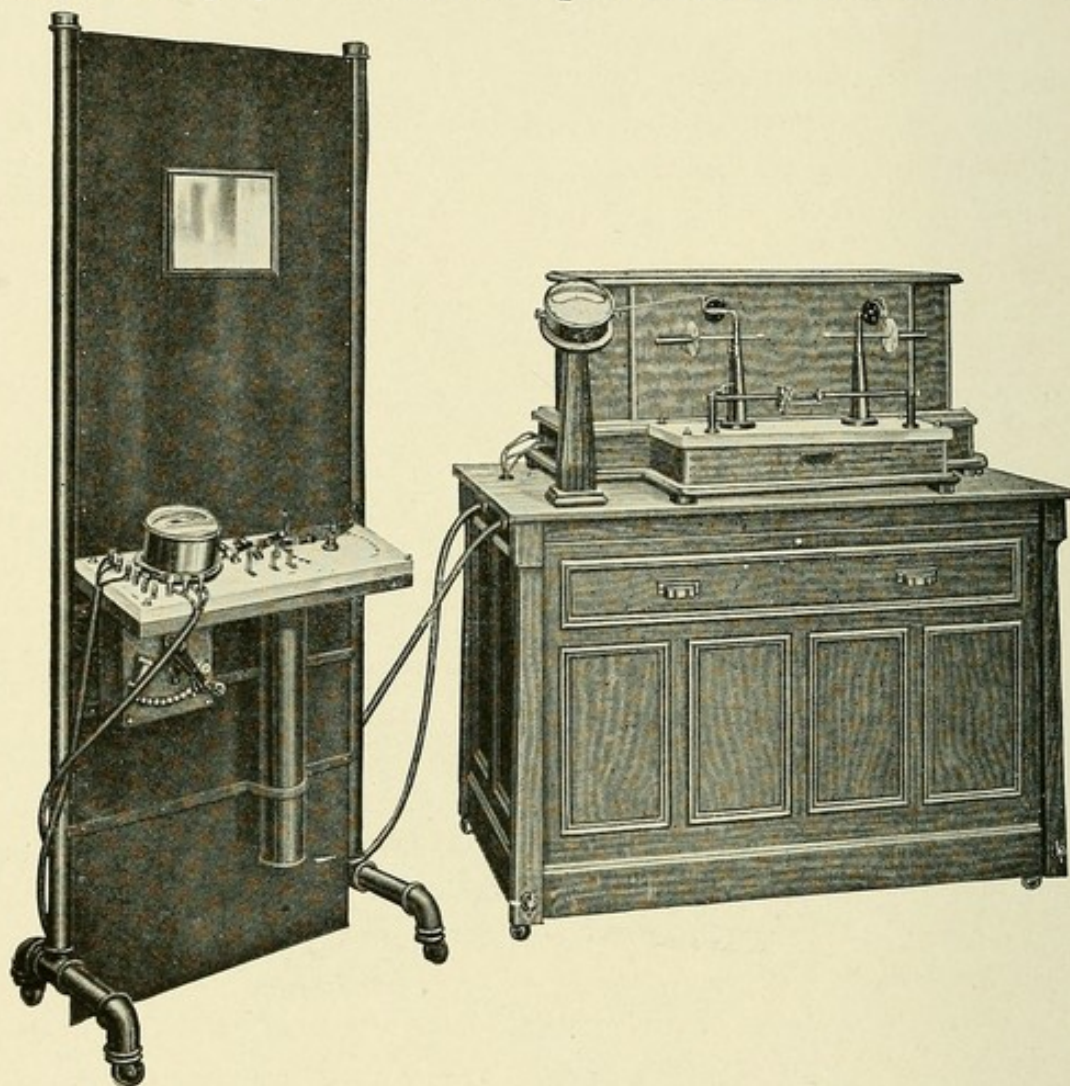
Large transformer as x-ray generator.
